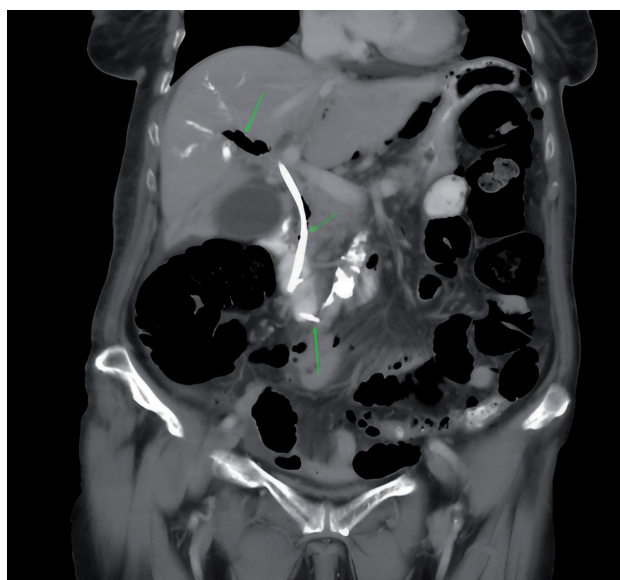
Coronal CT section of the abdomen with intravenous contrast showing the pneumoperitoneum after ERCP with the introduction of DBD (Stapfer IV).
